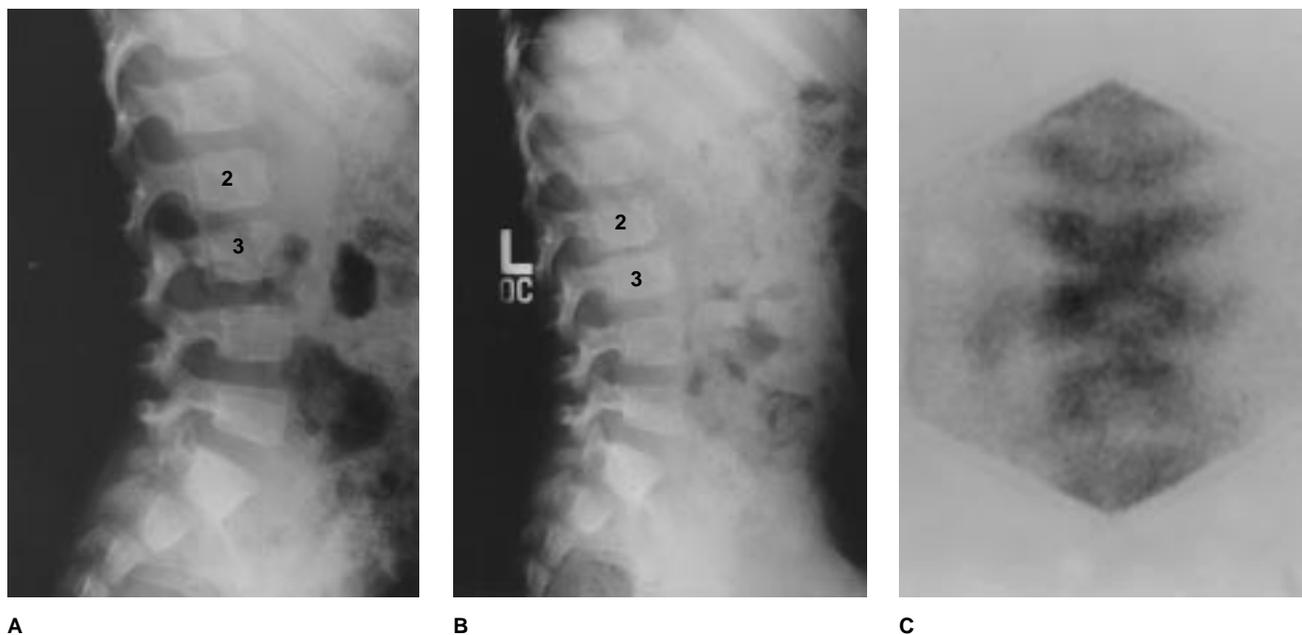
A, Lateral radiograph of the lumbar spine of a 2-year-old boy with low back pain for 1 week shows mild disk-space narrowing. B, Radiograph obtained 1 month later shows marked disk-space narrowing and endplate changes. C, Bone scan shows increased uptake in the adjacent endplates of L2 and L3.
